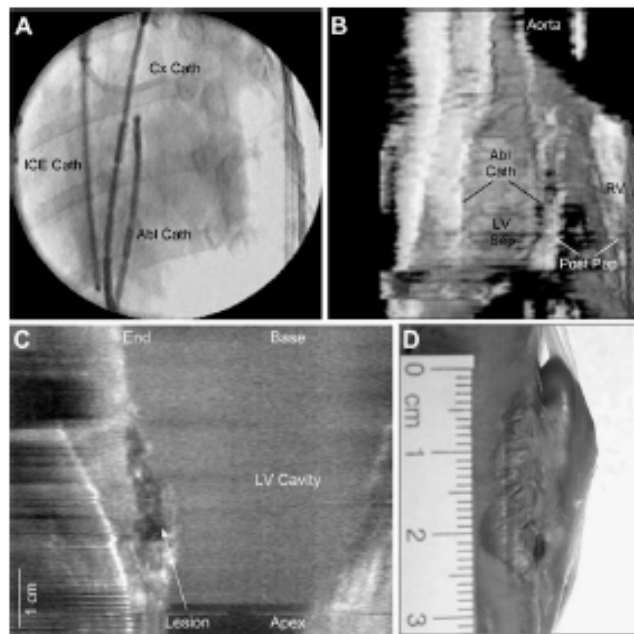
(A) Radiograph depicting a 14-electrode ablation catheter and an ICE catheter inside a sheath in the LV. A lumen catheter is placed in the circumflex coronary artery. (B) 3-D ICE reconstruction of the LV interior depicting the ablation catheter and anatomic features such as the LV septum and posterior papillary muscle. (C) 3-D MCE reconstruction of the LV depicting a linear lesion created by two adjacent electrodes in posterior region. (D) Corresponding longitudinal sectional view of the ablation lesion.
